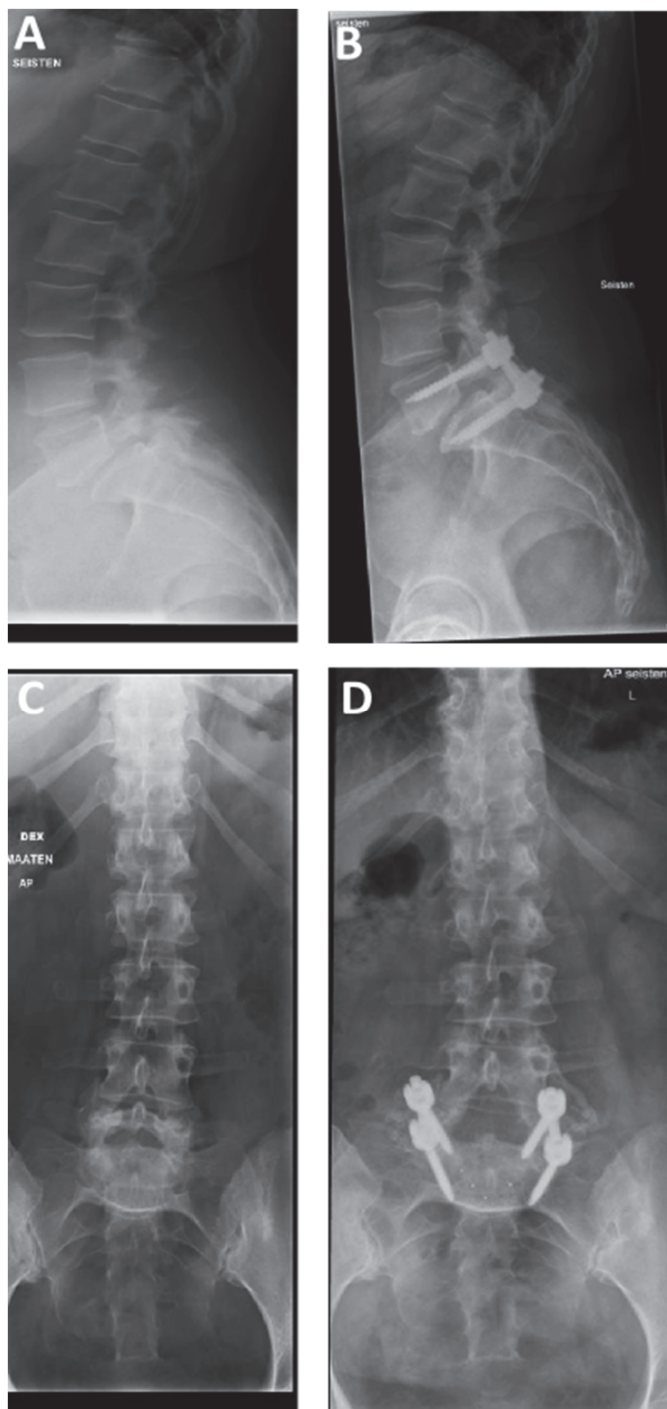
Lateral (A and B) and anterior-posterior (C and D) radiographs of a patient with isthmic spondylolisthesis taken before and after posterolateral fusion and TLIF. X-rays from Tampere University Hospital.
